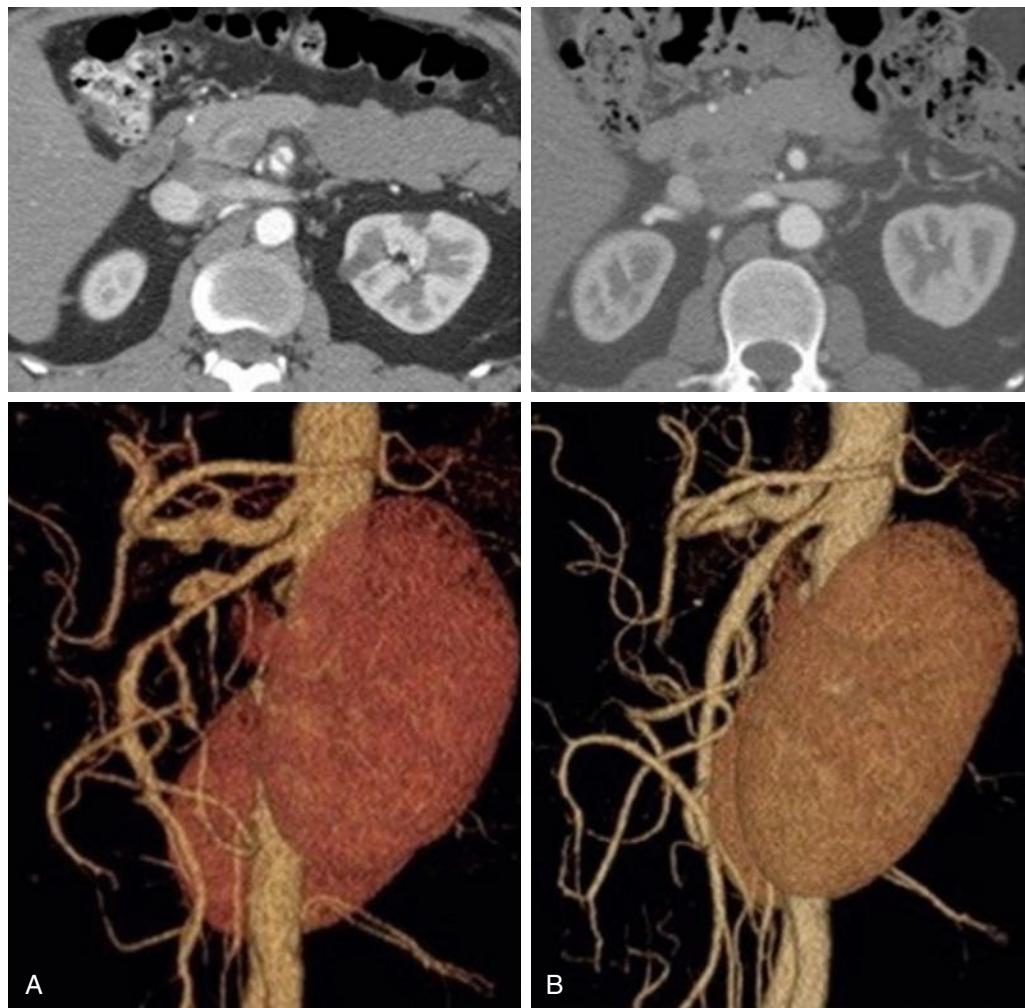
Computed tomography angiography demonstrating remodeling of spontaneous isolated superior mesenteric artery dissection before (A) and after (B) without intervention. (From Park YJ, Park KB, Kim DI, et al. Natural history of spontaneous isolated superior mesenteric artery dissection derived from follow-up after conservative treatment. *J Vasc Surg*. 2011;54:1727–1733.)
